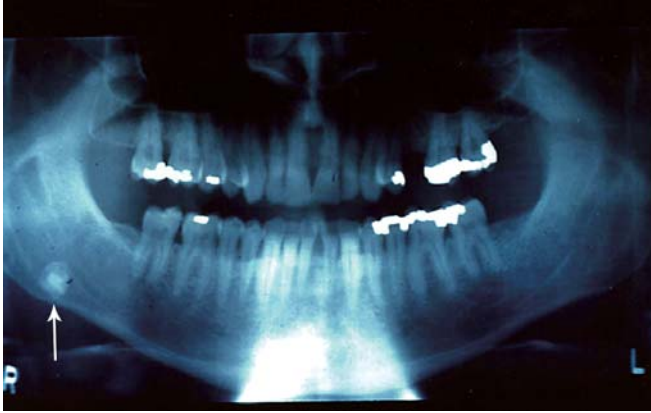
Radiograph showing salivary stone (Arrow) of the patient shown in Fig. 6.5
